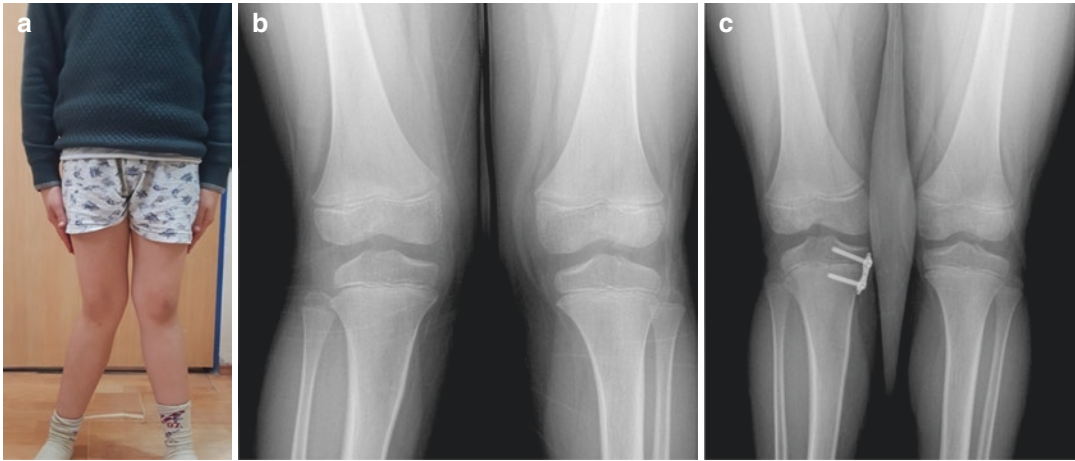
(a) A 6-year-old boy sustained a lateral tibial physal arrest after conservatively treated proximal tibia fracture. After 3 years of follow-up, the patient developed a genu valgum deformity namely “Cozen deformity” on the right side. (b) AP preoperative X-rays of both knees
